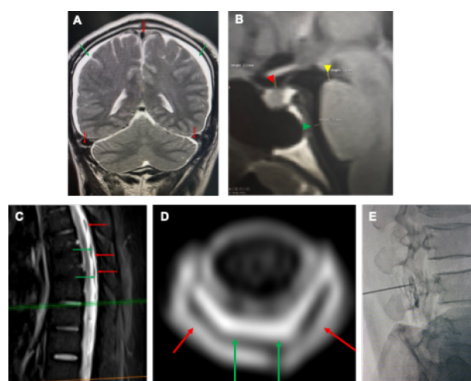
A) Coronal T2-weighted MRI shows subdural effusion (green arrow) and venous engorgement (red arrow). B) Sagittal T2-weighted MRI reveals effacement of the suprasellar (red arrowhead, pathologic ≤ 4 mm), prepontine cisterns (green
